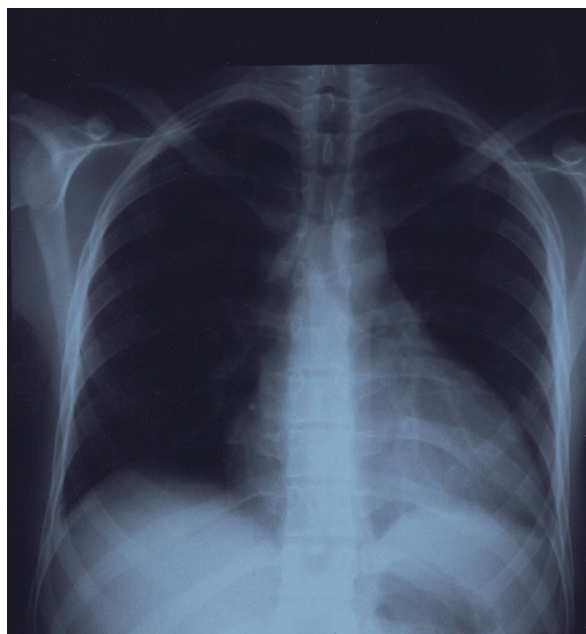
Chest radiograph shows an enlarged cardiac silhouette.
